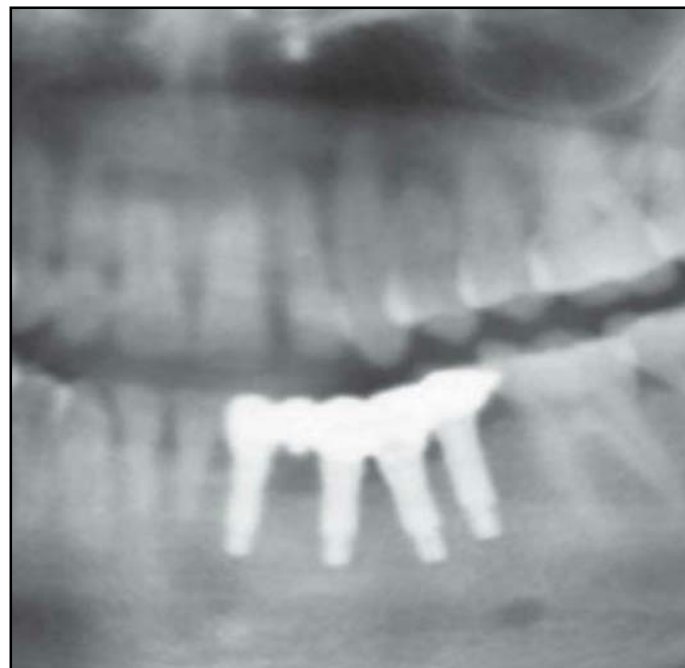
Radiographic view after prosthesis insertion.
